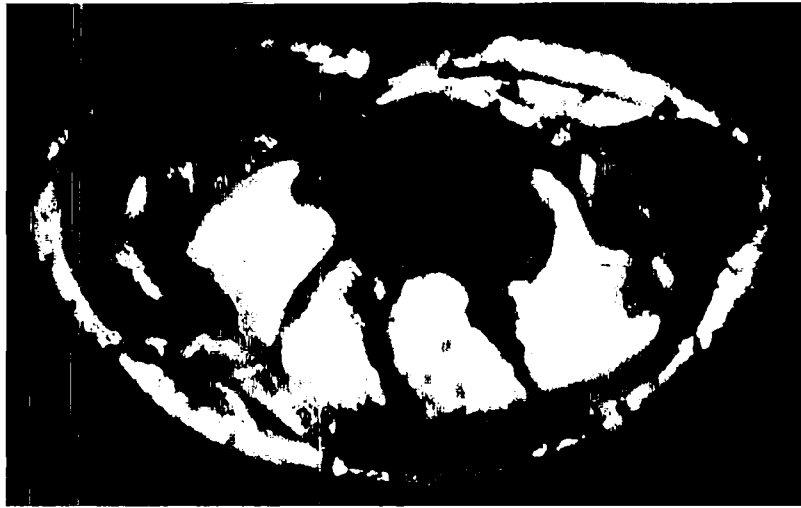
T-1 weighted MR imaging studies performed preoperatively, showing the superficial position of the median nerve, along with the transverse carpal ligament, and the rich reservoir of hypothenar fat.
